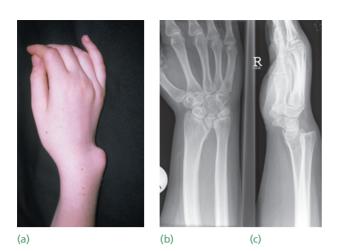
Madelung's deformity (a) Note the prominent ulnar head and radial tilt; (b) characteristic X-ray showing the increased slope of the radius and (c) subluxation of the ulna.
